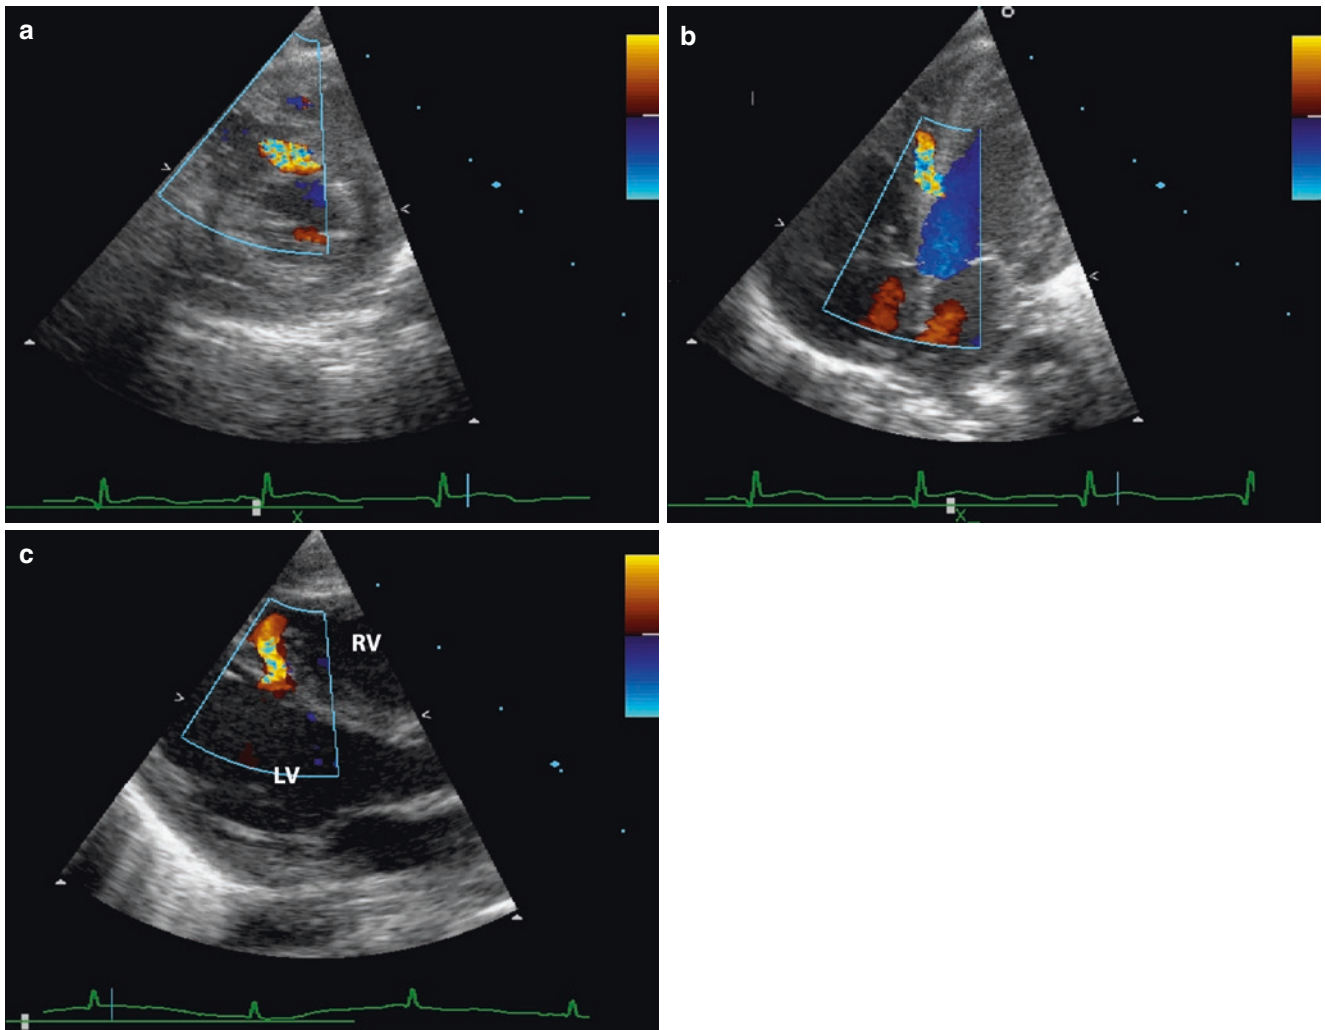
Restrictive midventricular VSD in the parasternal short-axis view (a), the apical four-chamber view (b) and in the parasternal long-axis view (c). *LV* left ventricle, *RV* right ventricle
